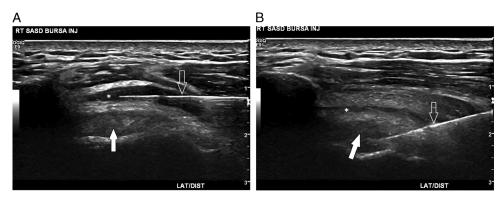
Sonographically guided prolotherapy injection for rotator cuff tendinopathy with long axis view of subacromial bursa (asterisk) and supraspinatus tendon (closed arrow). Acromion is located medially, to the left. A, Needle (open arrow) is directed in plane, lateral to medial, into the subdeltoid subacromial bursa. B, Needle is directed in plane, lateral to medial, into the tendinopathic supraspinatus tendon (closed arrow).
